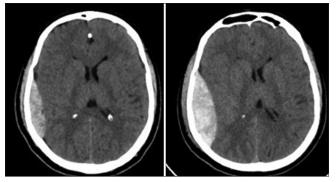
A 23-year-old male with Glasgow Coma scale 15 and small right temporal extradural hematoma (EDH) (left); repeat computed tomography showing significant enlargement of the EDH (right). He underwent surgery.
